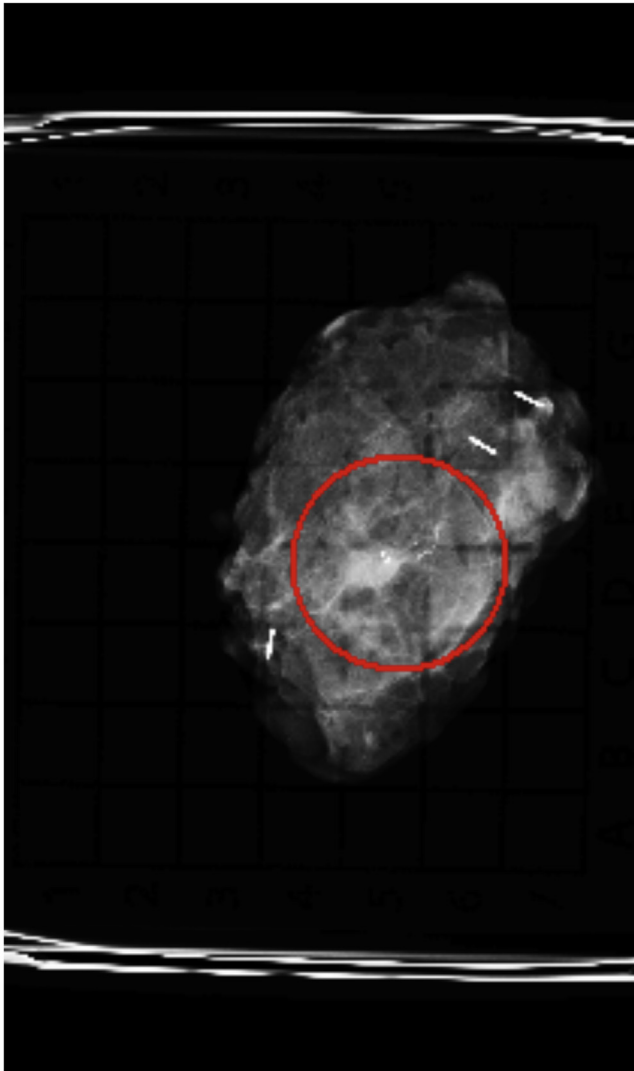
Radiographic examination showing the radicality of the infero-central lumpectomy.
